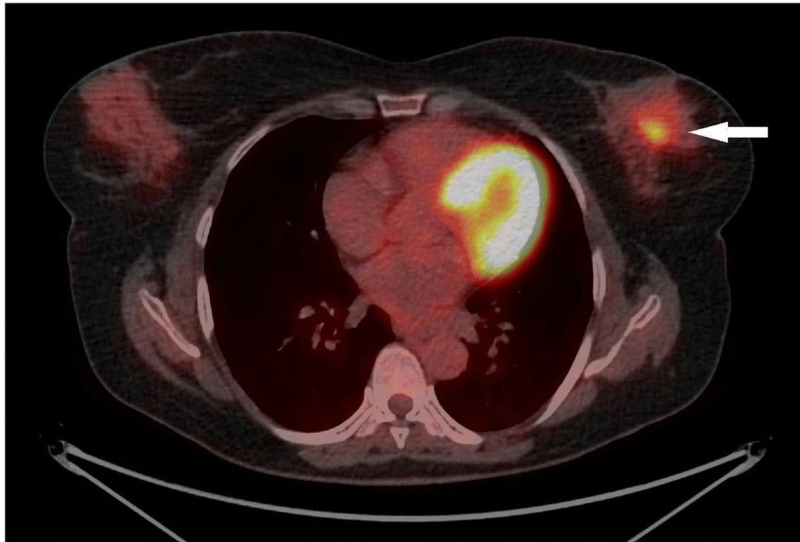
Axial F-18 fluorodeoxyglucose positron emission/computed tomography image of a patient with breast cancer, showing the primary tumor in the left breast (adapted by Iakovou et al.)
